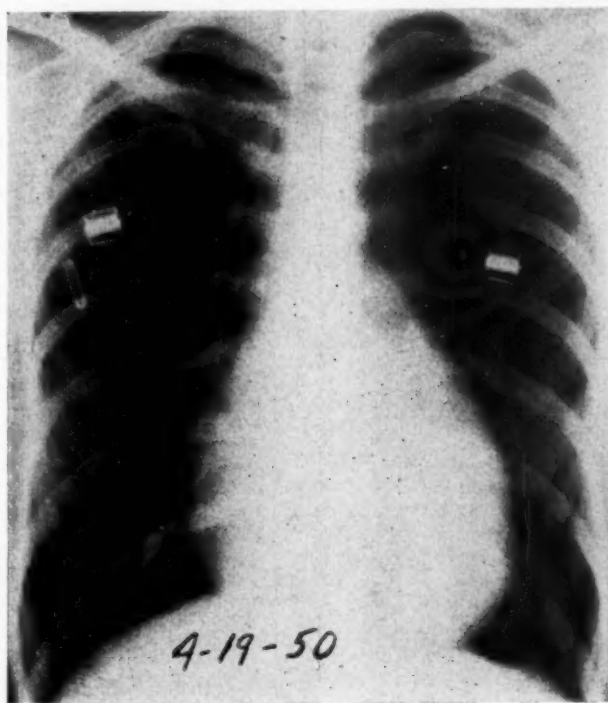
Chest x-ray showing cardiac enlargement.
